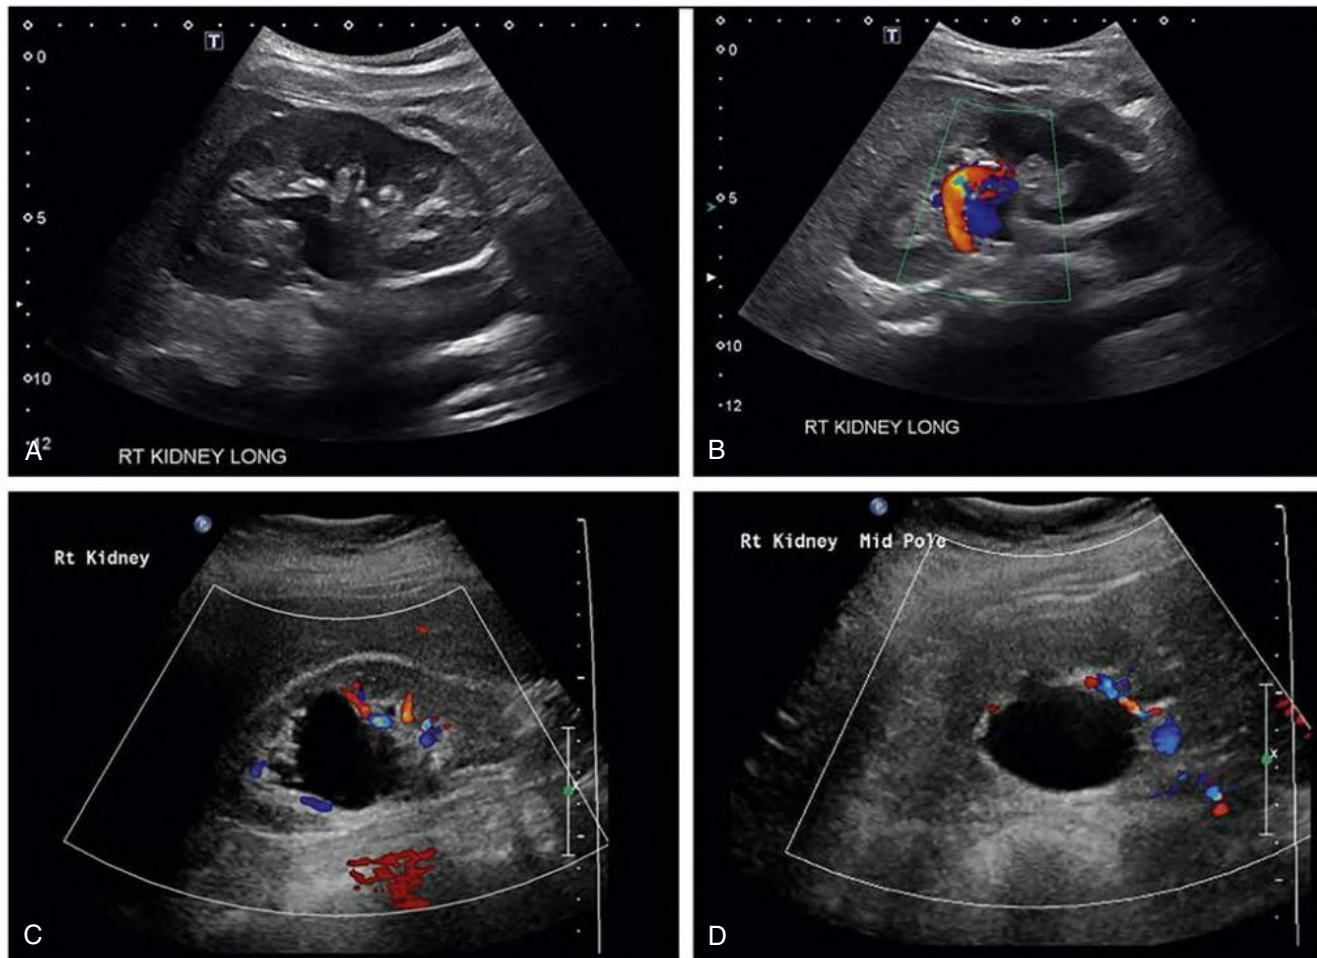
(A) Grayscale image of the kidney demonstrating an anechoic area mimicking mild hydronephrosis. (B) Color Doppler image of the same kidney demonstrating blood flow suggestive of vasculature (arteriovenous malformation in this case). (C–D) Longitudinal and transverse images of kidney demonstrating a large parapelvic cyst mimicking hydronephrosis.
